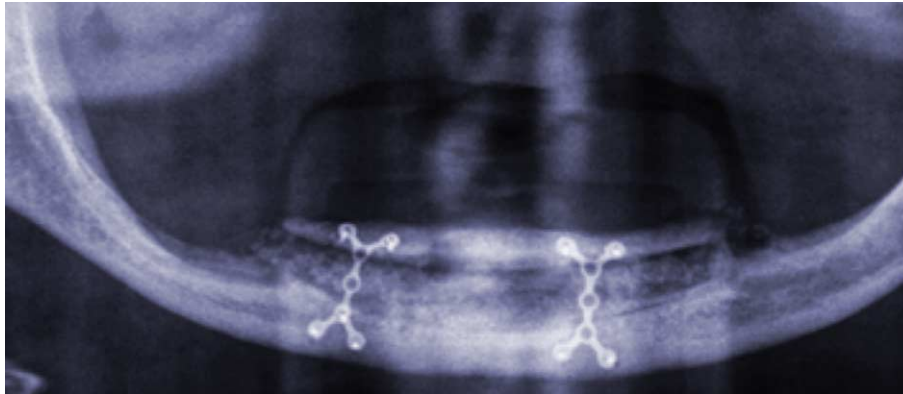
Orthopantomogram: immediate postoperative view.
